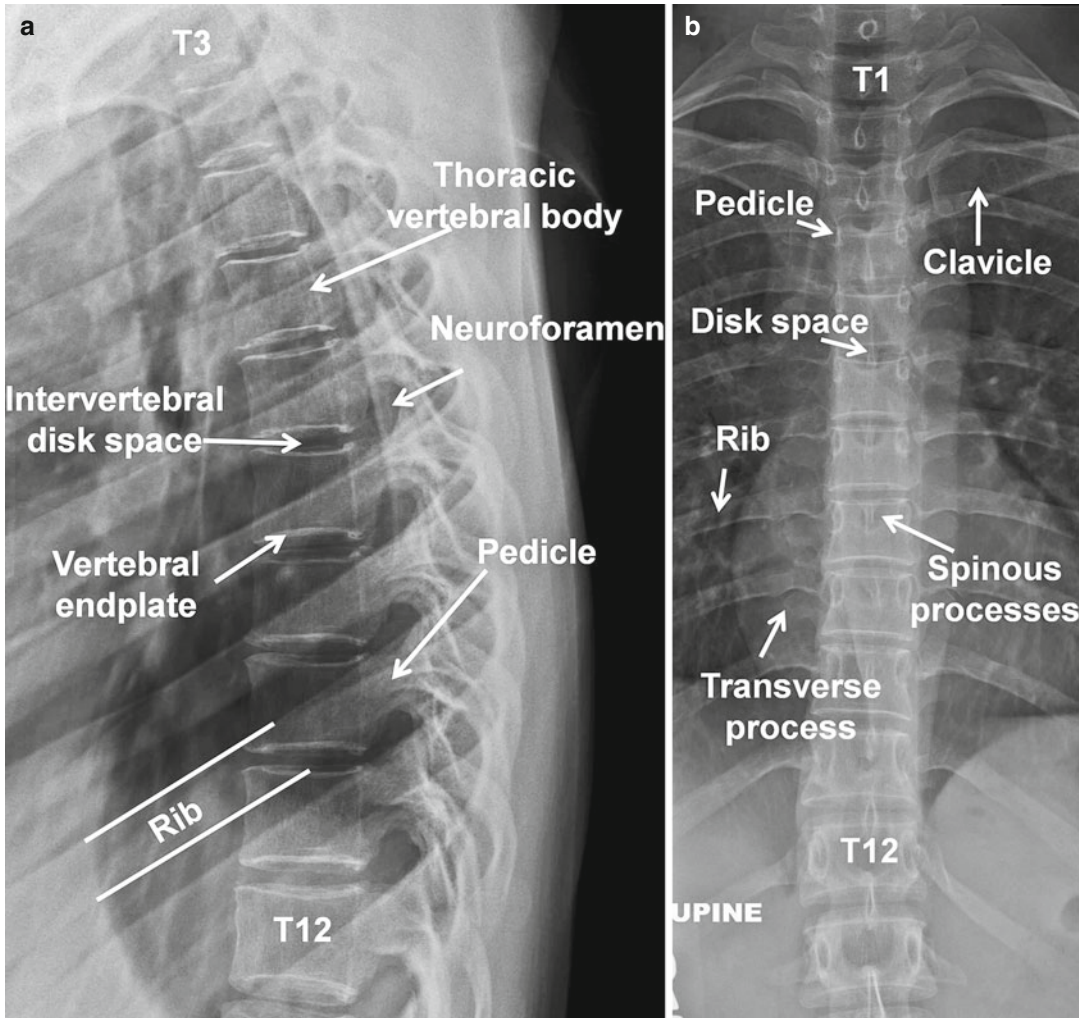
Lateral (a) and frontal (b) views of the thoracic spine, with pertinent labeled normal radiographic anatomy
